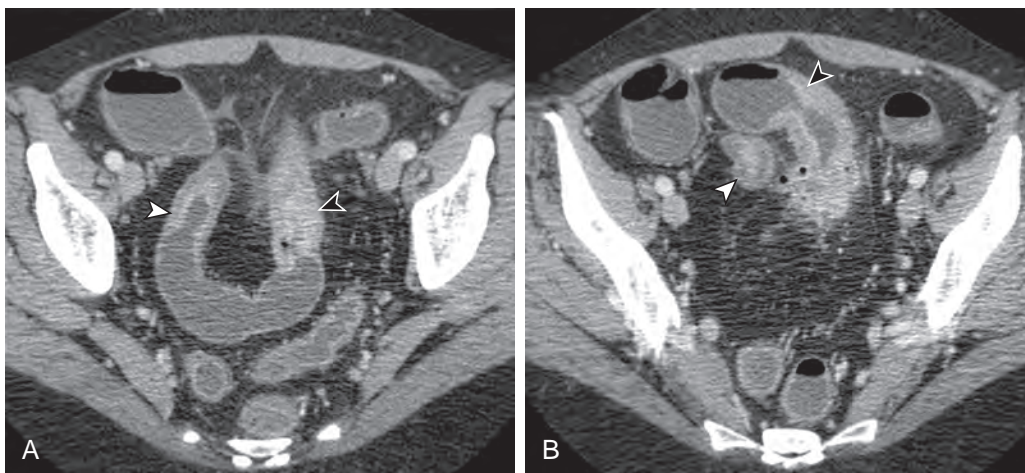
Diagnosing cancer in Crohn's disease. A, B. Axial CT scans in 41-year-old woman show mild wall thickening in the terminal ileum (white arrowhead). There is mural heterogeneity, with enhancement of the mucosa and edema in the submucosa. More proximally, an 8-cm segment of substantial wall thickening with homogeneous enhancement is seen (black arrowhead). B. There is proximal shouldering (black arrowhead). At surgery, Crohn's disease was found in the terminal ileum. The more proximal lesion was an adenocarcinoma. Good bowel distention and an IV contrast bolus are required to diagnose cancer in the presence of inflammatory bowel disease (white arrowhead).
